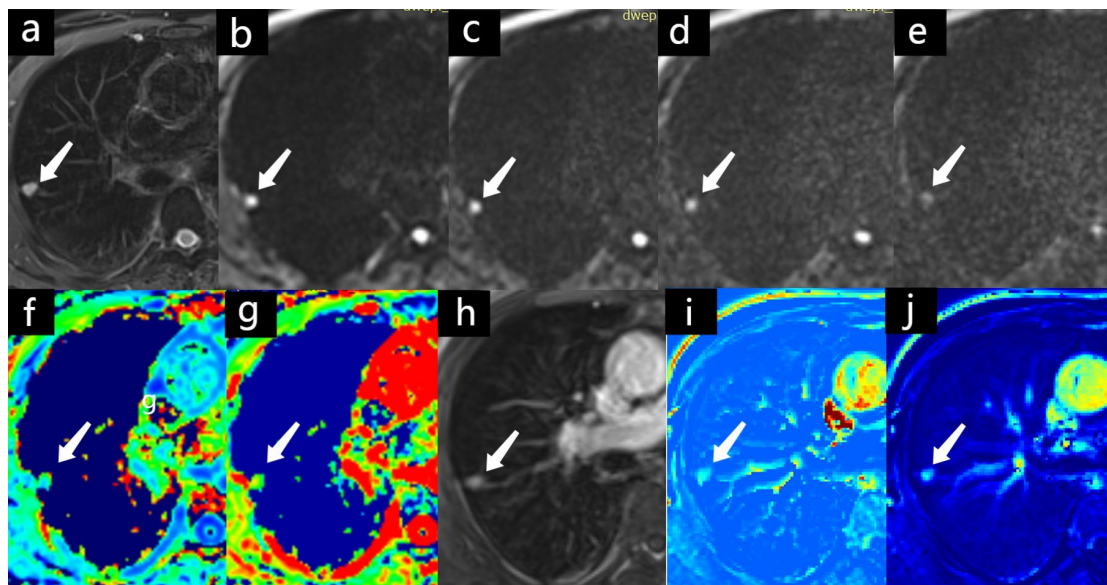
Representative case of a low to moderately differentiated adenocarcinoma (arrow) in the right upper lobe of lung of a 61-year-old male case. (a) Axi T2-weighted MR image shows the tumor (arrow) in the posterior segment of right upper lobe. (b-e) multi-b factor diffusion weighted imaging, $b=400,800,1400$ and 2000 s/mm^2 , respectively. (f) Kapp map of the SPN, Kapp value=0.74. (g) Dapp map of the SPN, Dapp value=1.76 mm^2/s . (h) DCE-MR imaging of one phase shows moderate homogenous enhancement of the nodule. (i) Ktrans map, $Ktrans=0.506$ min^{-1} . (j) iAUC map, $iAUC=18.43$ $mmol.kg^{-1}.s$
